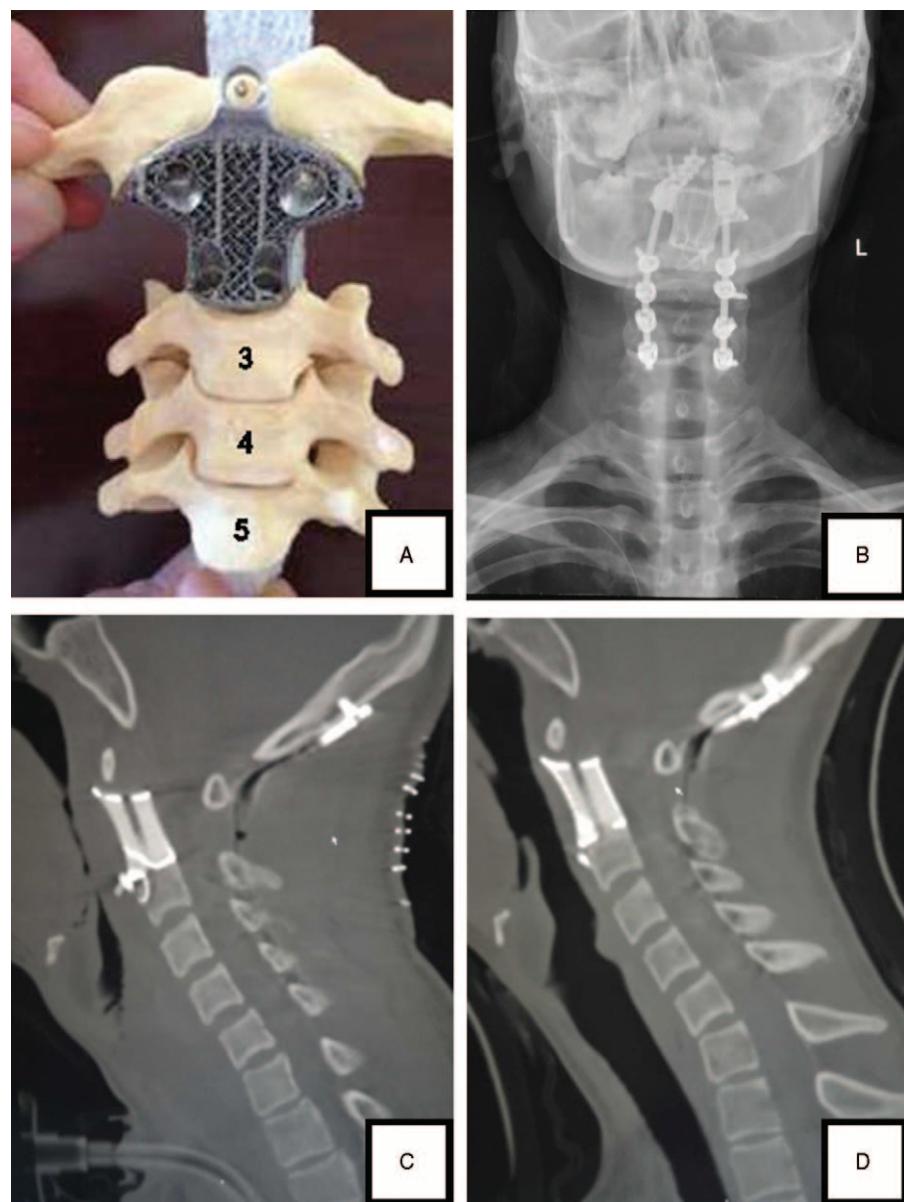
A, Model and B, postoperative X-ray demonstrating how the self-stabilizing artificial vertebral body was inserted between C1 and C3. C, Sagittal reconstruction immediately postoperatively and D, at the 1-year follow-up showing evidence of implant osseointegration, no subsidence or displacement of the construct, and no local recurrence of the tumor.
